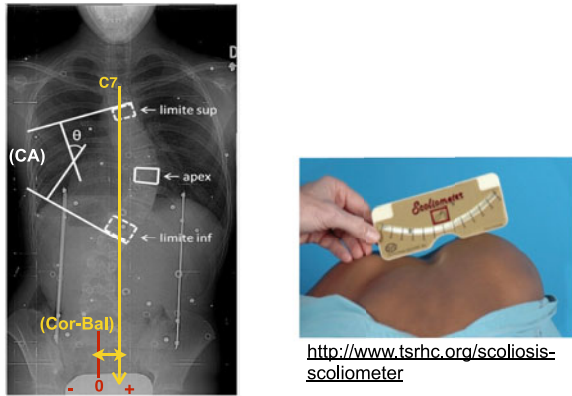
Visual description of the clinical measurements for scoliosis diagnosis. To the left, a radiographic image of a scoliotic female patient from Saint-Justine hospital. The Cobb angle (CA) is defined as the angle between the lines perpendicular to the upper and lower vertebrae delimiting the main thoracic curve. The coronal balance (Cor-Bal) is defined as the lateral distance between the central sacral vertical line (in red color) and the line drawn downwards from the mid-point of the C7 vertebrae (in yellow color). To the right, a web image showing the apical trunk rotation angle (rib hump) at the back measured by the scoliometer.
